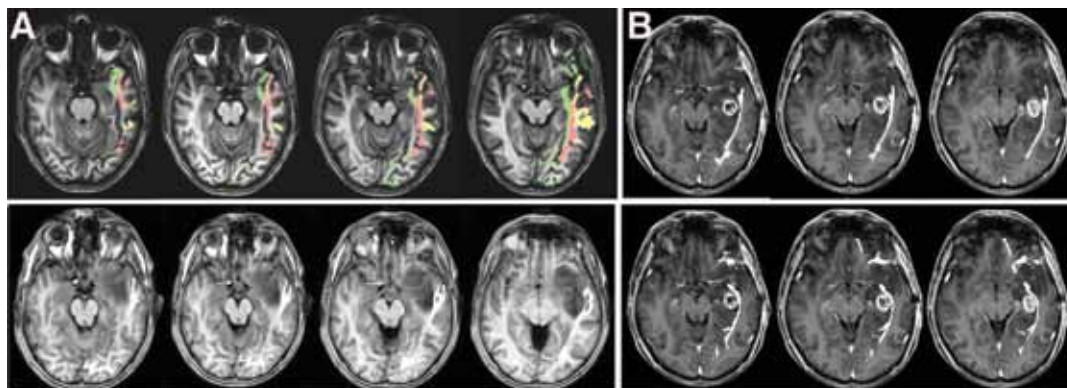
Diffusion tensor imaging–FT reconstruction of the ILF. A: A case of a low-grade temporal oligodendroglioma. Diffusion tensor imaging–FT reconstructions of the IFO (green ROIs), ILF (red ROIs), and SLF (yellow ROIs) were merged with T1-weighted MR images (results shown in upper panels). Images with only the DT imaging–FT reconstruction of the ILF (white ROIs) were fused with T1-weighted MR images (results show in lower panels). Both sets of images show that the tracts were inside the tumor mass and can be depicted as separate fascicles. B: A case of a large left temporal high-grade glioma. The DT imaging–FT reconstruction of the ILF is shown in the upper panels and that of the IFO in the lower panels. The ILF and IFO (white ROIs, upper and lower panels, respectively) were fused with postcontrast T1-weighted MR images. In this case, the ILF was intermingled with the IFO, and they could not be functionally separated during surgery.
